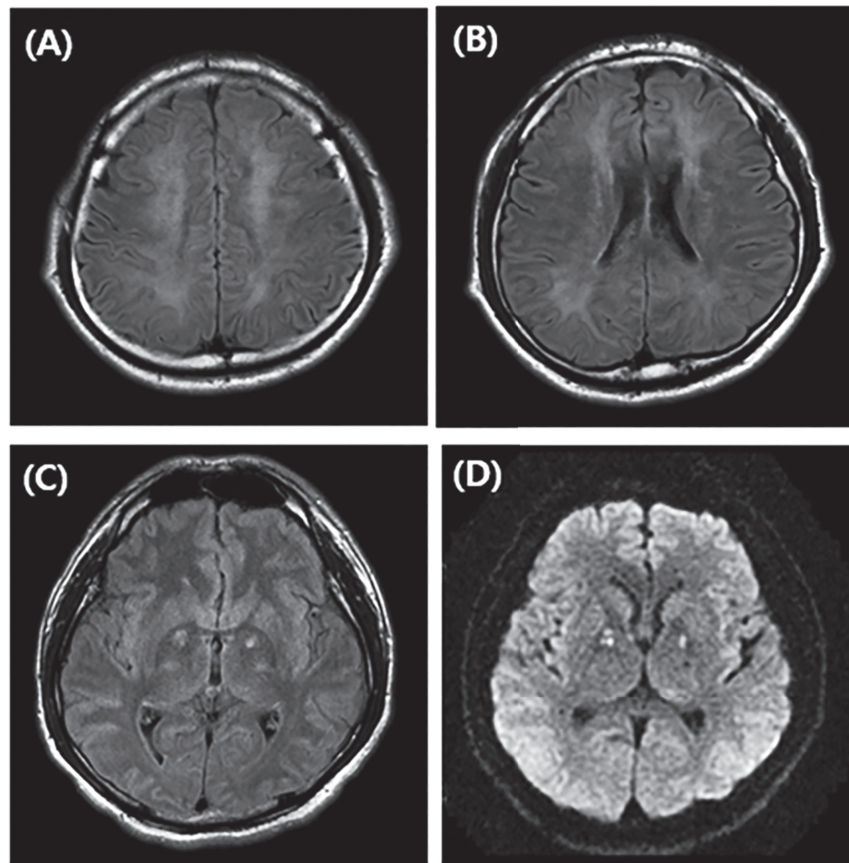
Brain magnetic resonance image upon readmission
